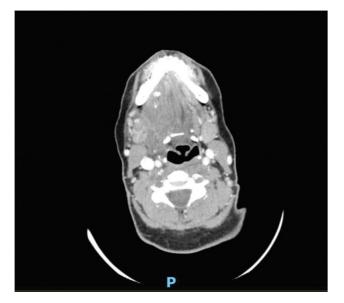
Computed tomography (CT) image showing a high-density collection compatible with hematoma adjacent to the lingual cortex of the right mandibular body, measuring $4 \times 4 \times 3$ cm (anterior-posterior [ap] \times craniocaudal [cc] \times transverse [t]) without causally exceeding the mylohyoid muscle (MH). The described collection exerts a mass effect displacing the midline of the airway at level of the oropharynx.
